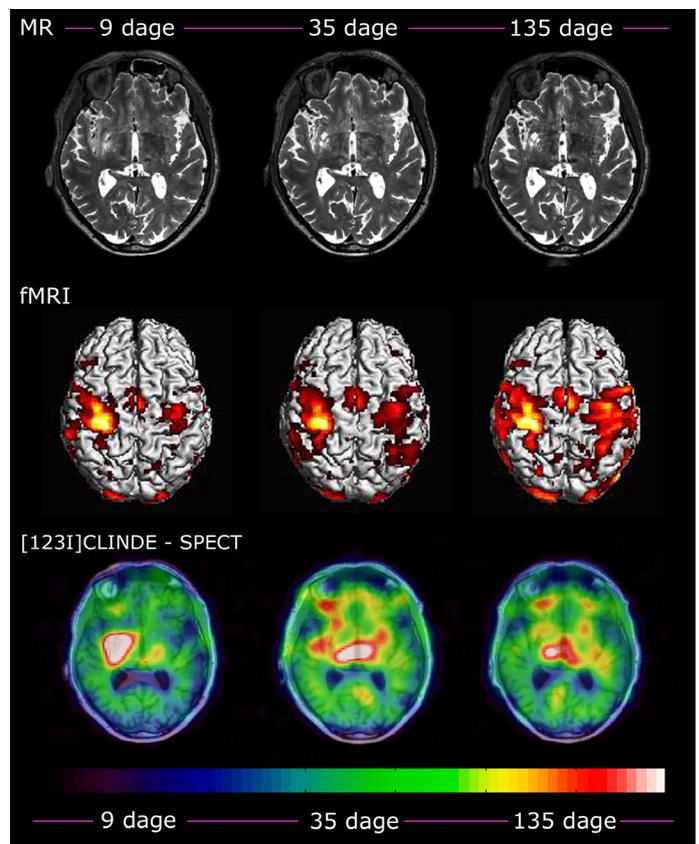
T2 weighted MRI (upper panel), functional MRI from fist closure motor paradigm (middle panel) and [¹²³I]CLINDE-SPECT (lower panel) images from an apoplexia cerebri patient scanned 9 (left), 35 (middle) and 135 (right) days after stroke. On the T2 weighted MRI the initial damage is seen as a hyper intensity in the right thalamus and insula cortex. The functional MRI shows ipsilesional motor activation and increasing contralesional motor activation from 9 to 135 days, when the patient is instructed to perform fist closures. The [¹²³I]CLINDE-SPECT images overlaid with T1 weighted MRI images show a lesional and perilesional increase in tracer binding at 9 days. At 35 days, the [¹²³I]CLINDE binding has decreased lesionally and perilesionally but increased in the ipsilesional and contralesional thalamus. After 135 days, the [¹²³I]CLINDE binding has decreased again, in concordance with the clinical recovery. Figure from [26], Copyright © The Author 2015.
